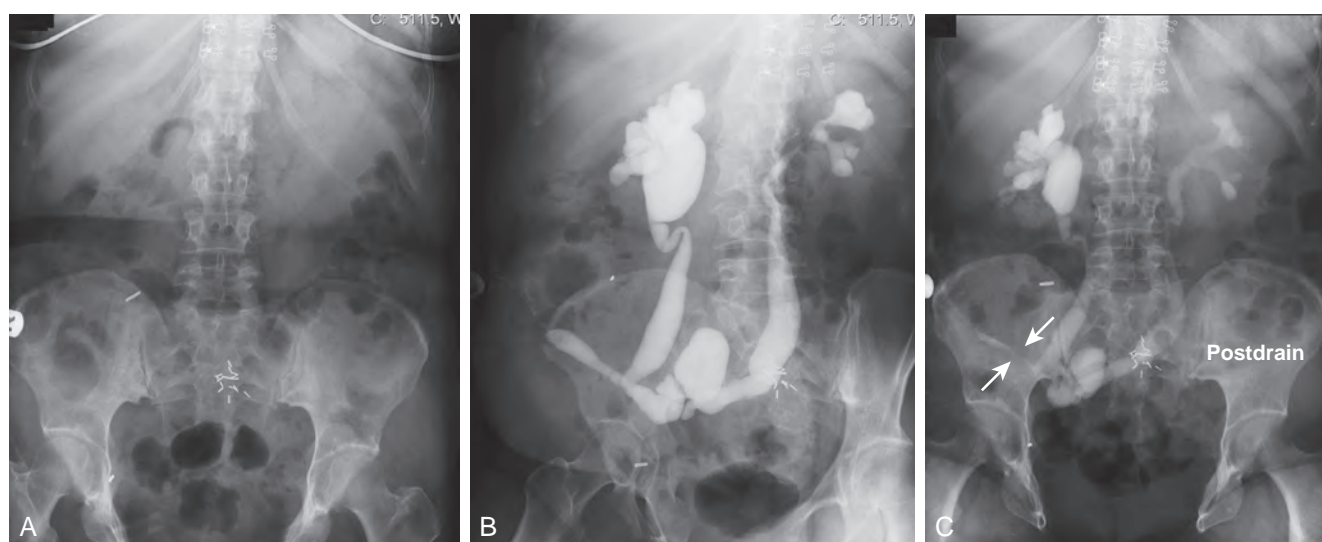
Loopogram in a patient with epispadias/exstrophy and ileal conduit urinary diversion. The plain film (A) shows wide diastasis of the pubic symphysis. After contrast administration via a catheter placed in the ileal conduit, free reflux of both ureterointestinal anastomoses is demonstrated (B). A postdrain radiograph (C) demonstrates persistent dilation of the proximal loop, indicating mechanical obstruction of the conduit (arrows).
